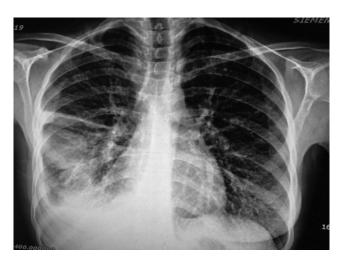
Chest X-ray after treatment with octreotide during hospital admission.
